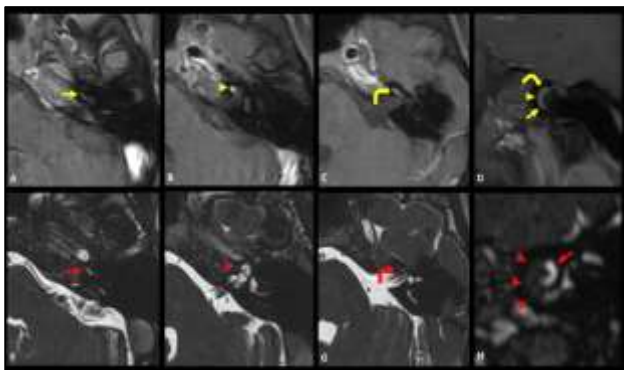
(A-H): ICS in left cochlea after 5-year MR follow-up. Axial fat-saturated gadolinium-enhanced T1-weighted images and balanced fast field-echo images coronal fat-saturated gadolinium-enhanced T1-weighted image and parasagittal balanced fast field-echo reconstruction through left cochlea. Enhancing schwannoma anteriorly in basal turn (yellow arrows), second turn (yellow arrowheads), and upper part of (curved yellow arrows). Normal signal intensity.
